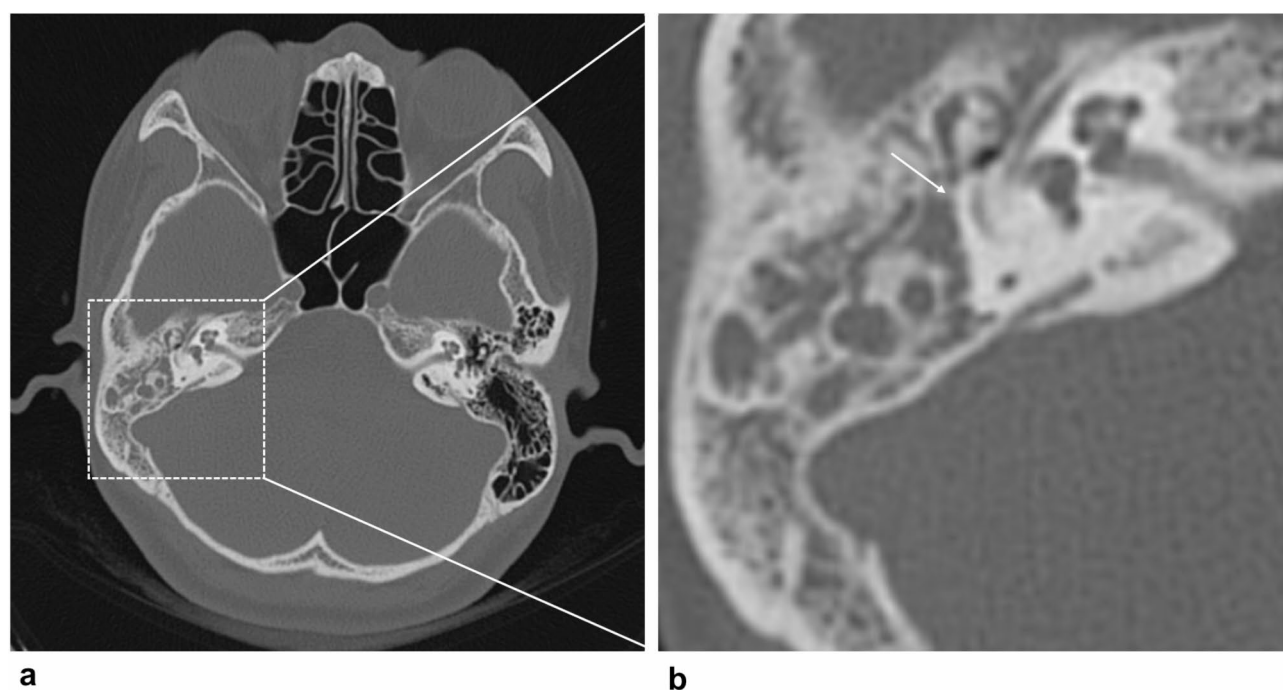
(a) Preoperative axial computed tomography (CT) scan of the temporal bone and (b) its local enlarged image shows soft tissue density in the aditus ad antrum (white arrow) causing obstruction.
